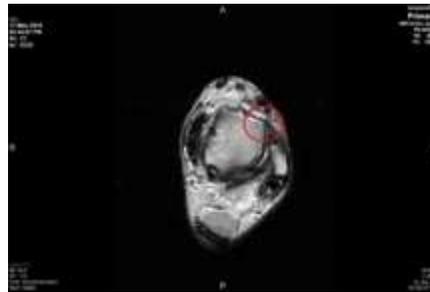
MRI left ankle (axial) T2-weighted image. ATFL appears thickened and heterogenous hyperintense suggestive of a high-grade tear.
